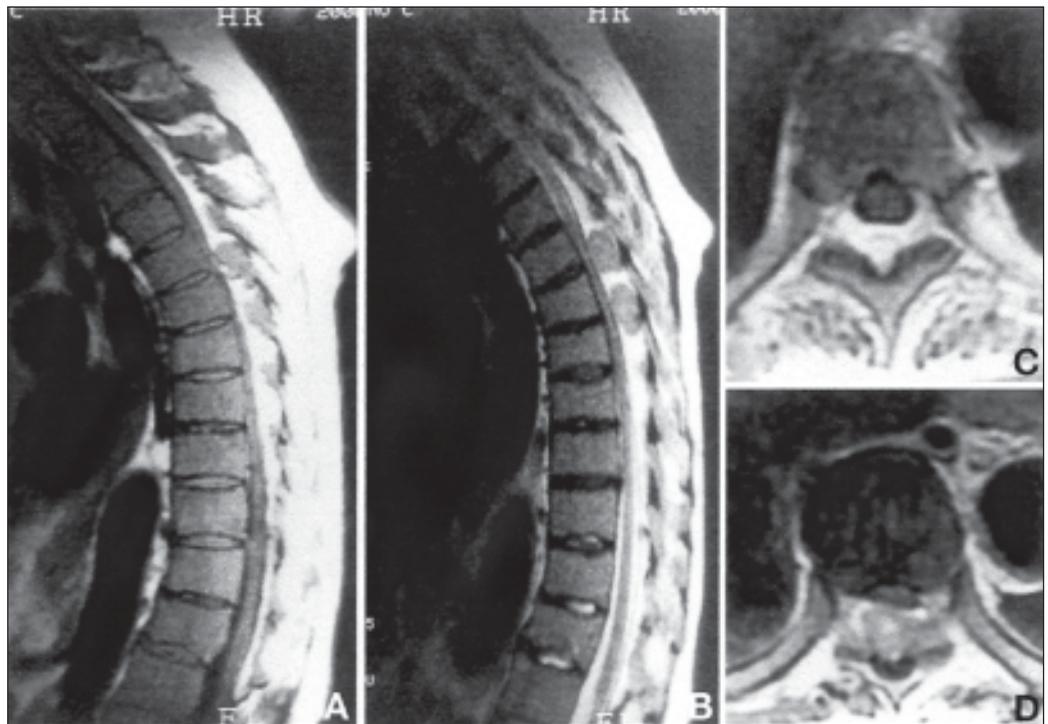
A: T_1 -weighted magnetic resonance image showing multiple extradural masses, extending from T-2 to T-9, isointense to the spinal cord. In particular, large posterior epidural masses are present from T-4 to T-8, compressing the cord. Note the thinning of the thoracic spinal cord on the sagittal view. B: T_2 -weighted magnetic resonance image showing the epidural masses as mixed intensity. C, D: Axial T_1 -weighted magnetic resonance images (C: T4-5 intervertebral level, D: T6-7 intervertebral level) showing heterogeneous enhancement after gadolinium administration. (after Ohta)
